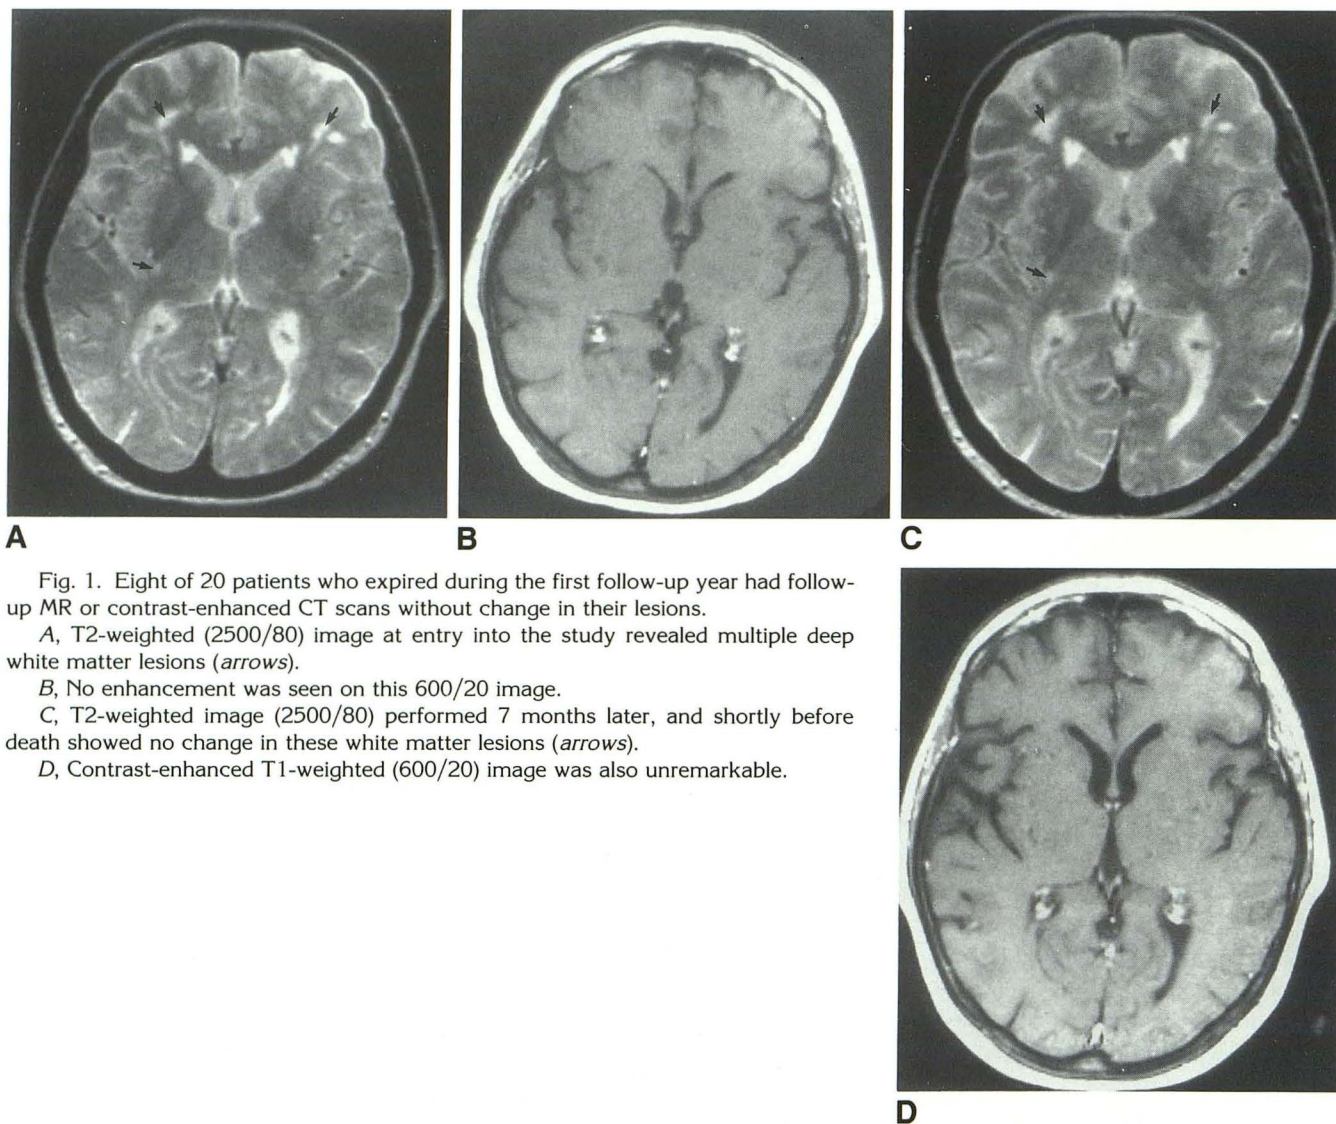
Eight of 20 patients who expired during the first follow-up year had follow-up MR or contrast-enhanced CT scans without change in their lesions.
